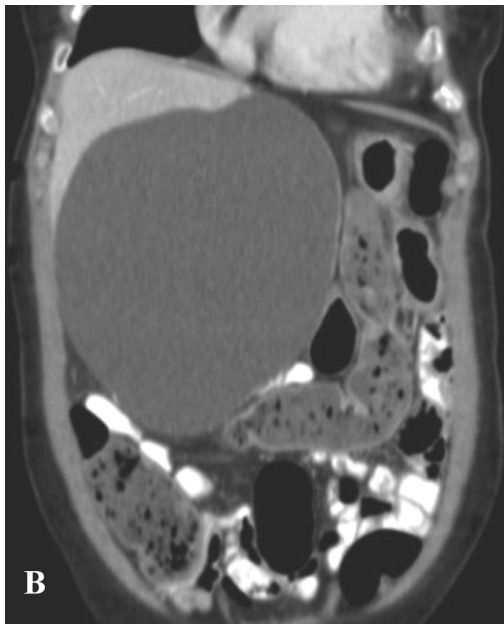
Cystic mass from CT scan of case 3
